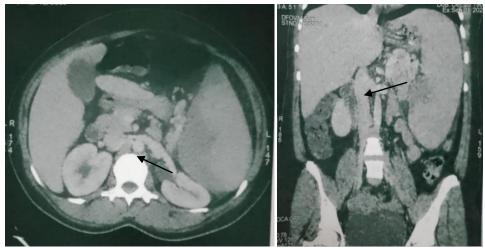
2: CT scans: large spleen (21cm long axis) with heterogeneous enhancement and hypodense areas; 5cm subcapsular hematoma (black arrow).
